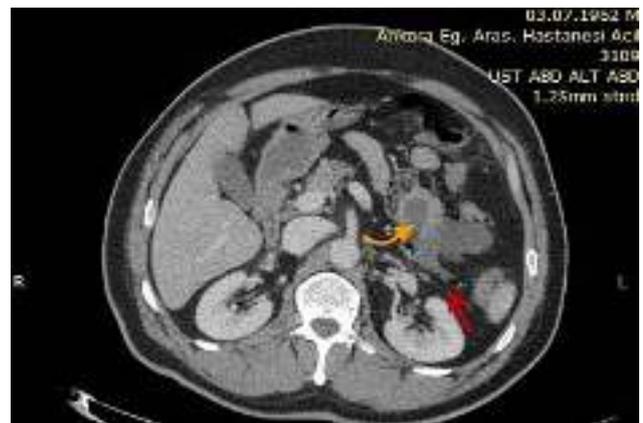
Axial contrast enhanced CT image showed distended small bowel (yellow arrow) between the stomach and pancreas and mild intra-abdominal fluid (red arrow).
